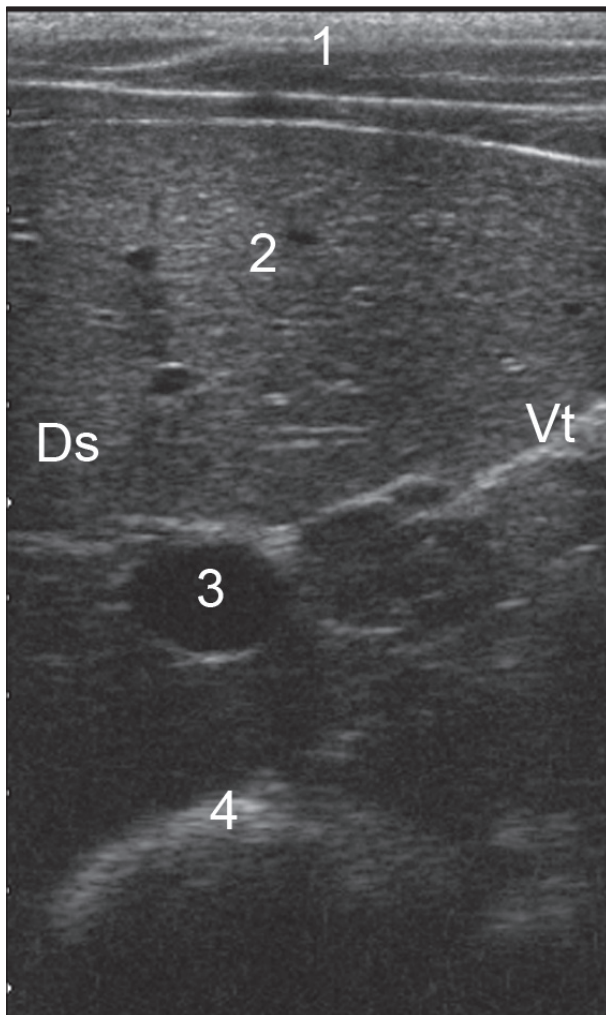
Ultrasonogram of the omasum and liver of a calf. The omasal wall appears as a curved echoic line, and the liver lies dorsolaterally and adjacent to the omasum. A 5.0 MHz linear transducer was used to scan the 8th intercostal space on the right. 1 Abdominal wall, 2 Liver, 3 Portal vein, 4 Omasum, Ds Dorsal, Vt Ventral.
